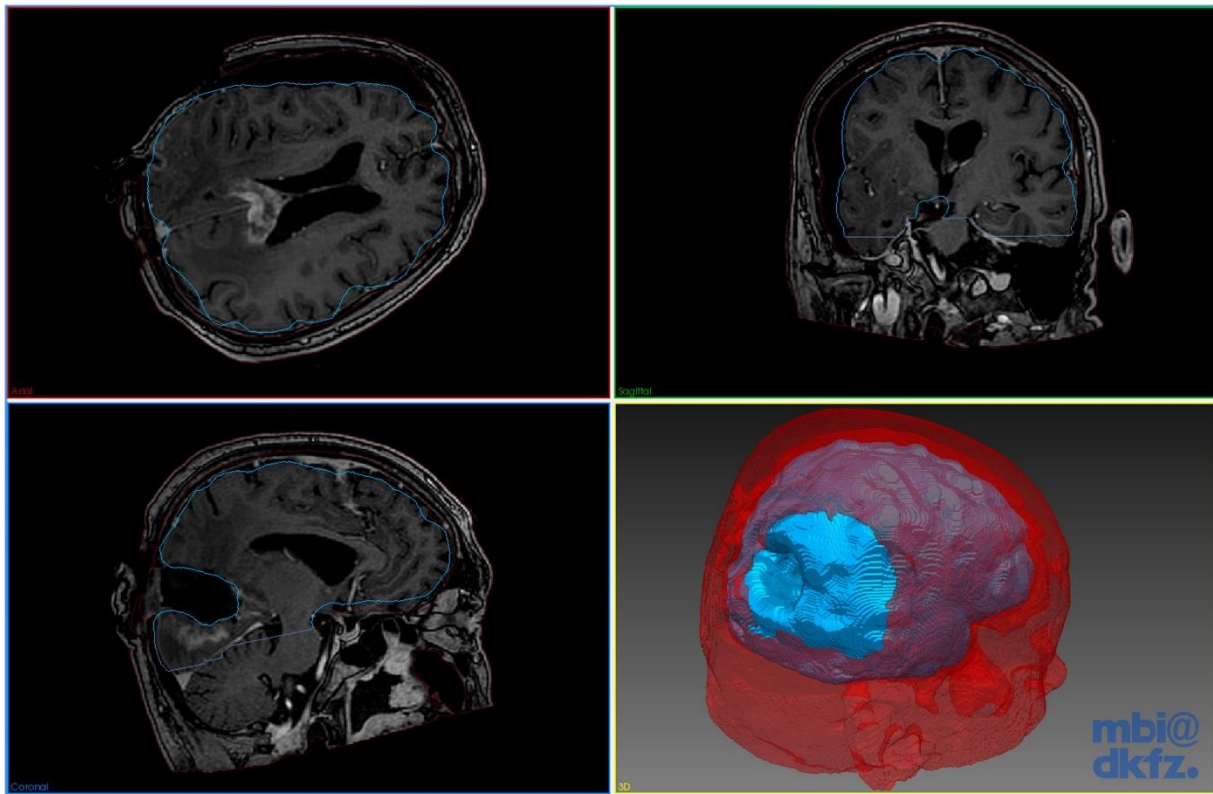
Screenshot of the MITK software: axial, sagittal and coronal view of an intraoperative MRI. 3D reconstruction of the brain's patient in blue and other tissues in red (such as skull, fat, eyes, nose, ears).
